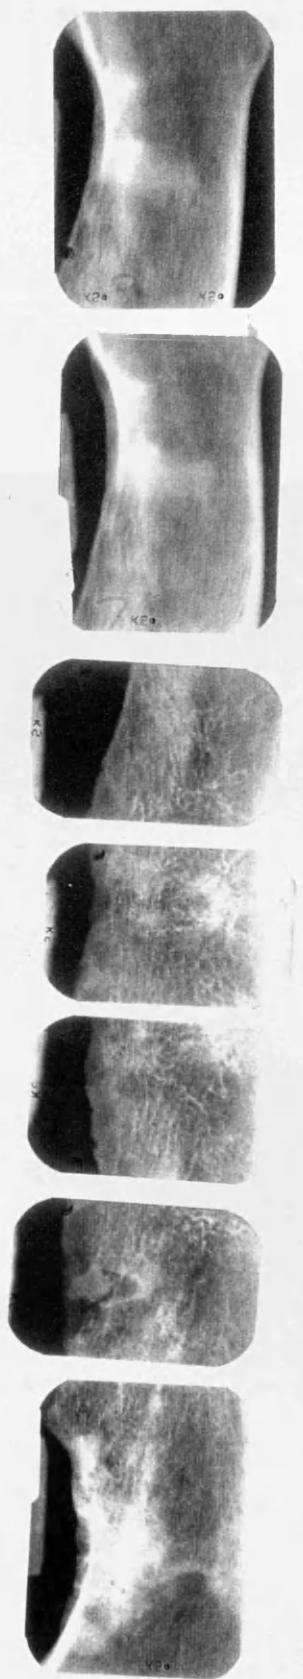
Radiographs of edentulous mandible
